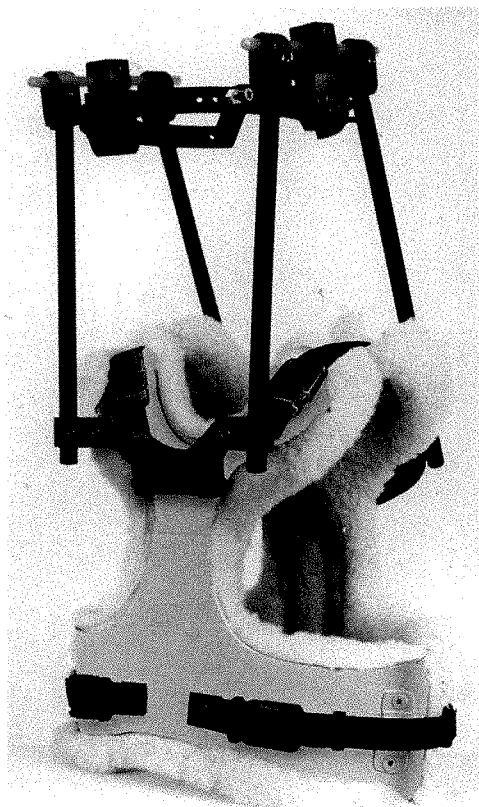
Halo vest composed of nonferromagnetic, nonconductive materials can be used during MR imaging.
